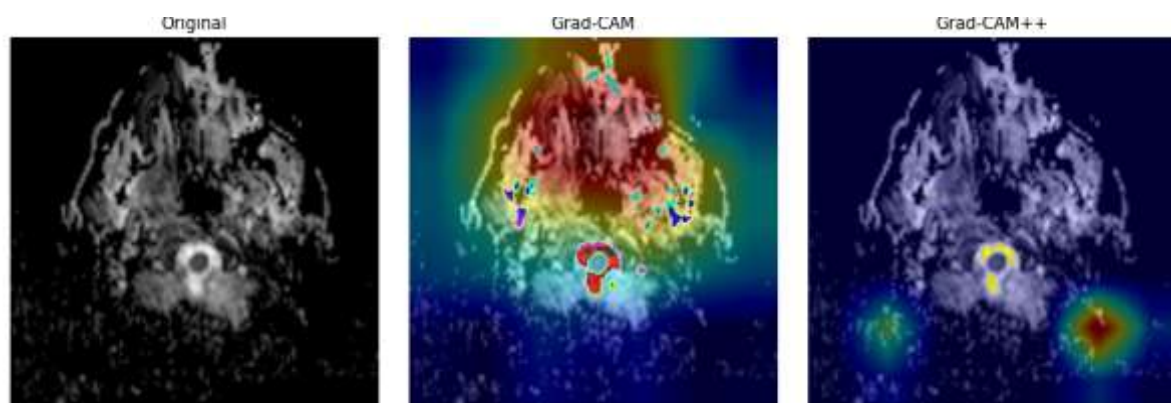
Grad-CAM and Grad-CAM++ visualization for a further representative Alzheimer's MRI slice using ResNet50.
